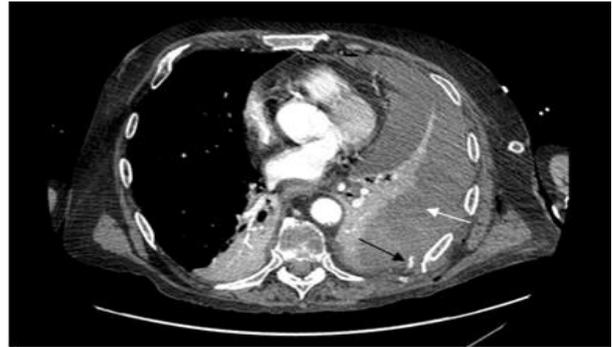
Computed Tomography with contrast (arterial-phase) scan demonstrating extravasation from the left 7th intercostal artery (black arrow) and massive haemothorax (white arrow).
